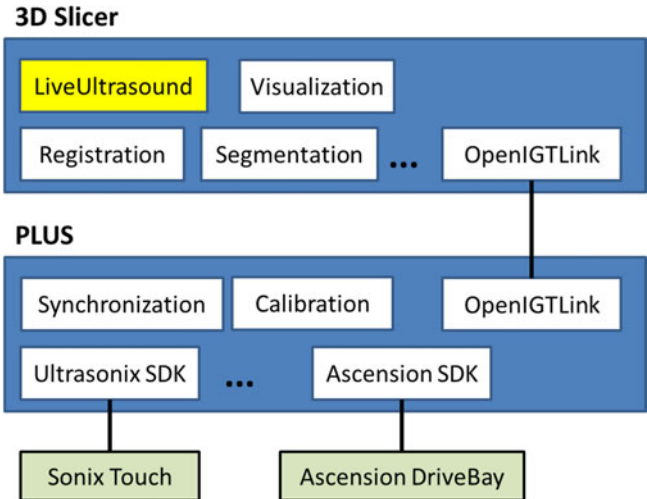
Software components of the navigation software. The LiveUltrasound Slicer module is specifically developed for tracked US snapshot navigation of needles. Note that all system components are parts of the PLUS or the 3D Slicer open-source software platforms.
